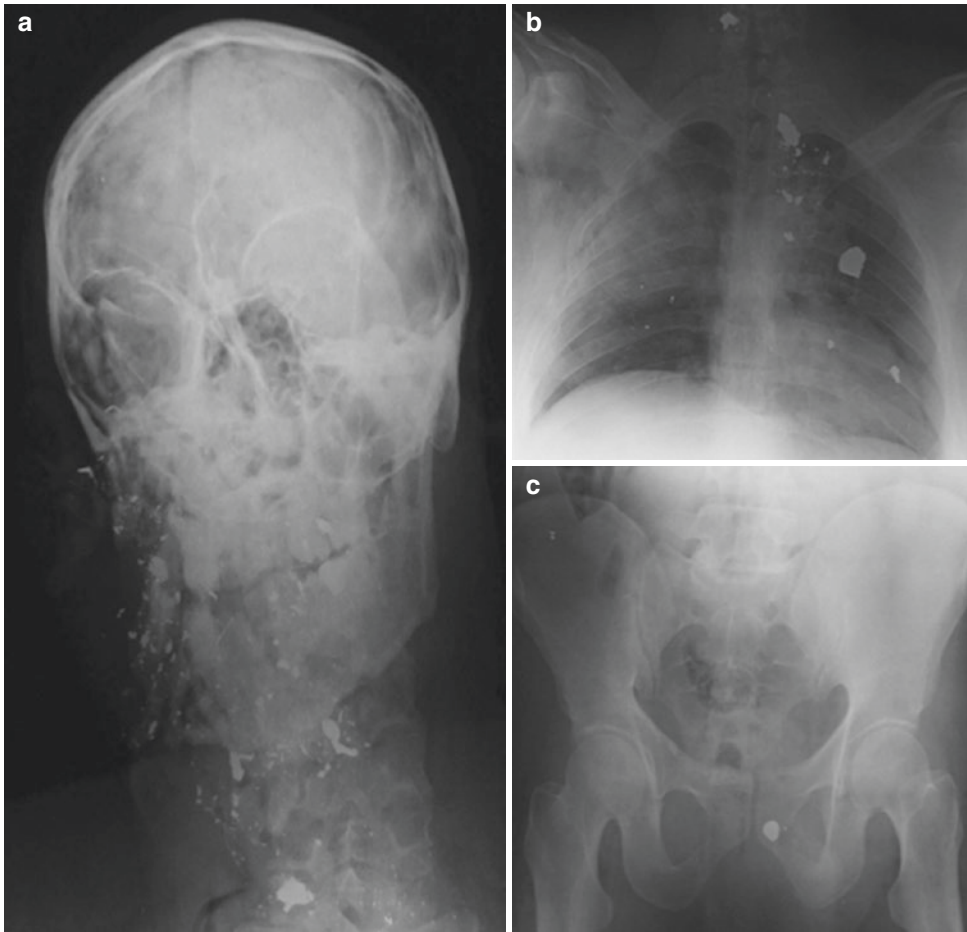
Localization metallic foreign bodies with conventional X-Rays on craniocervical region (a), thorax (b), and hip region (c)
